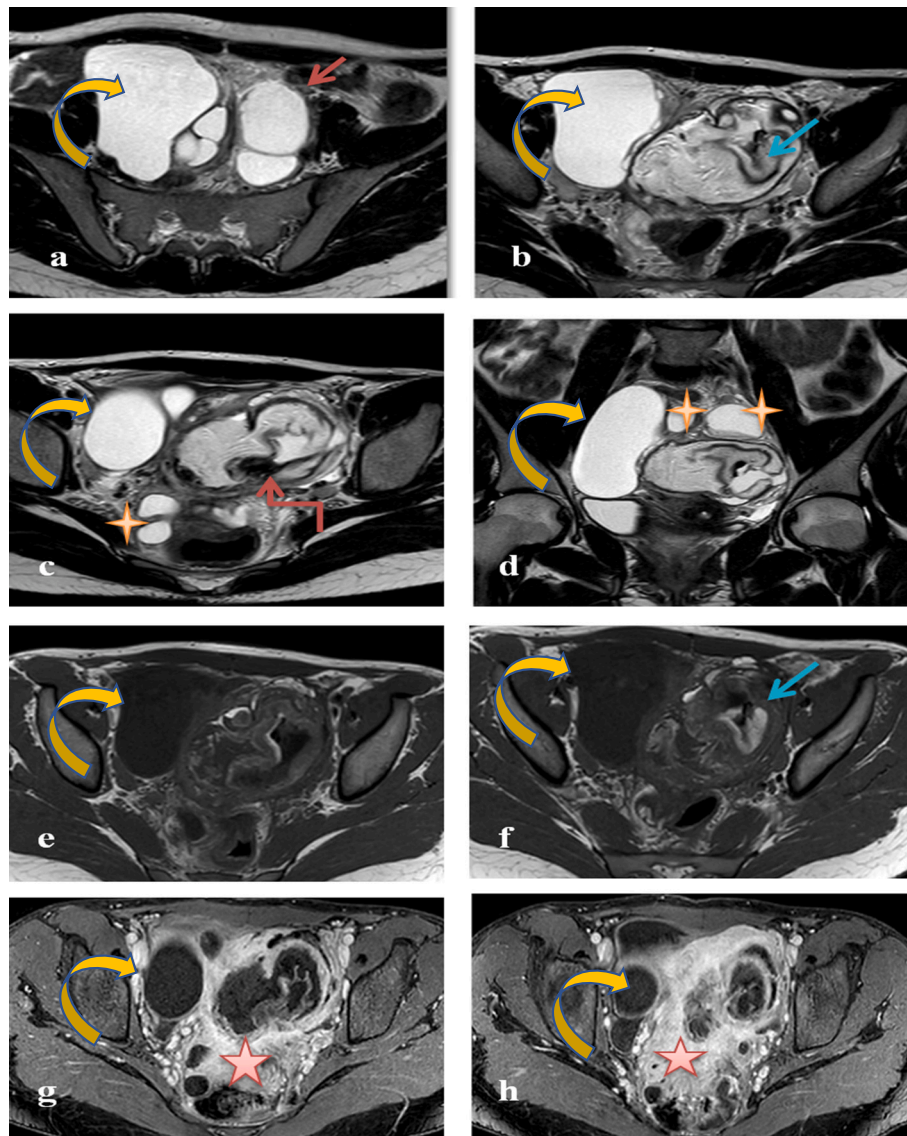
Pelvic MRI: axial T2W (a,b,c) and coronal T2W (d), T1W (e–f) and T1 with fat saturation and gado: left sided mass with fat areas (blue arrow) and calcification (angled arrow) associated to diffuse fat stranding with intense enhancement (red star) and multiple collections (orange star). Note the cystic mass of the right ovary, classified O-RADS 2(curved yellow arrows).
